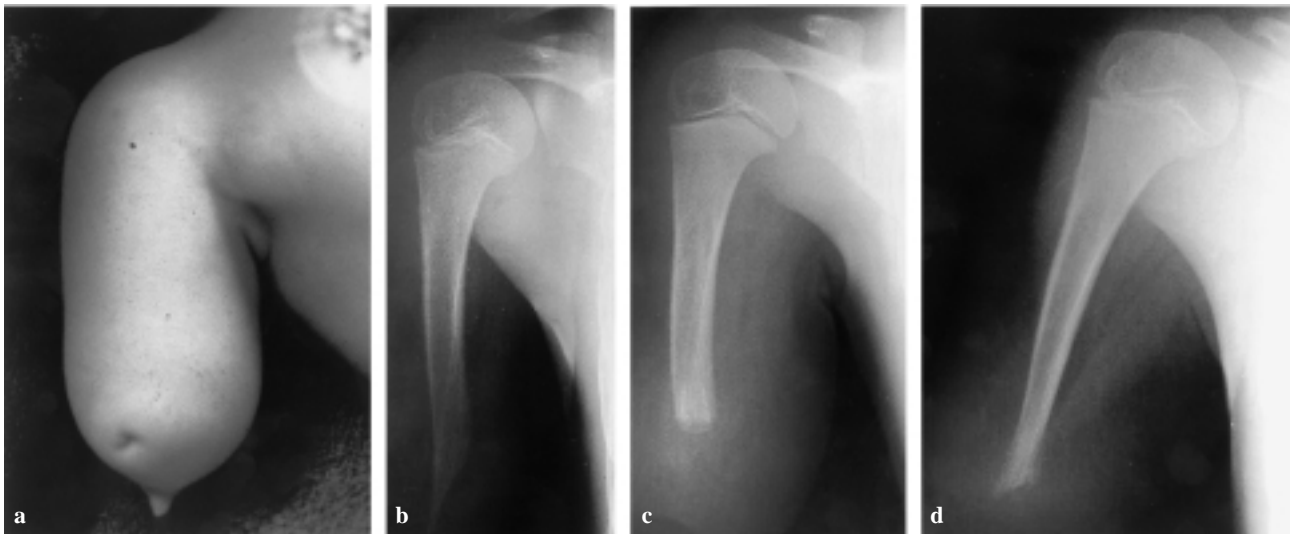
Clinical aspect of the overgrowth (a), radiographical aspect preoperatively (b) and postoperatively after 18 months (c) and four years (d).
